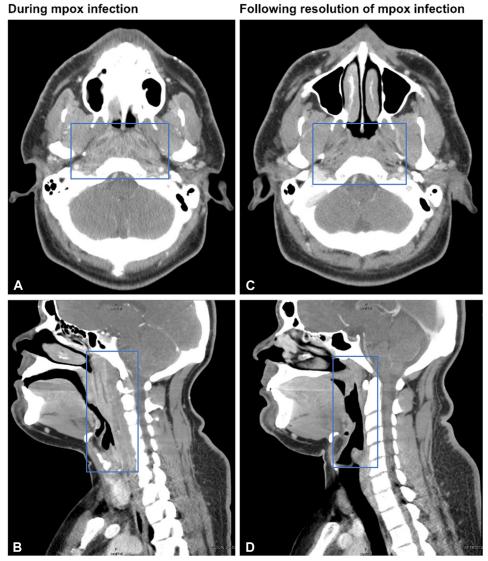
Nasopharyngeal soft tissue thickening on CT neck resolved following mpox treatment. A, Diffuse symmetric soft tissue thickening in the nasopharynx during active mpox infection. B, Nasopharyngeal airway narrowing during active mpox infection. C and D, Reduction in nasopharyngeal soft tissue thickening and clearing of nasopharyngeal airway 7 months following mpox treatment. *CT,* Computed tomography.
